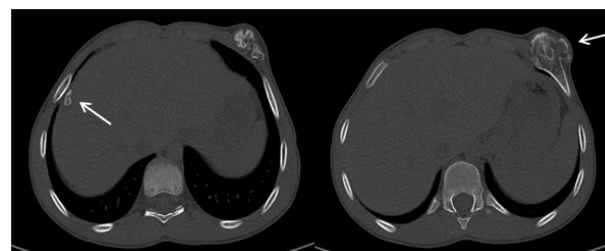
Thoracic CT scan (Axial) Showing Two Growths of Bone Extending Outwards and Originating from the Anterior Arches of the 7th both Left and Right Rib.
